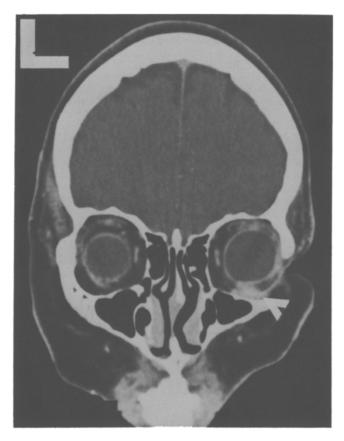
Orbital CT showing enlargement of the rectus inferior muscle and the obliquus inferior muscle (arrow) of the right eye.
